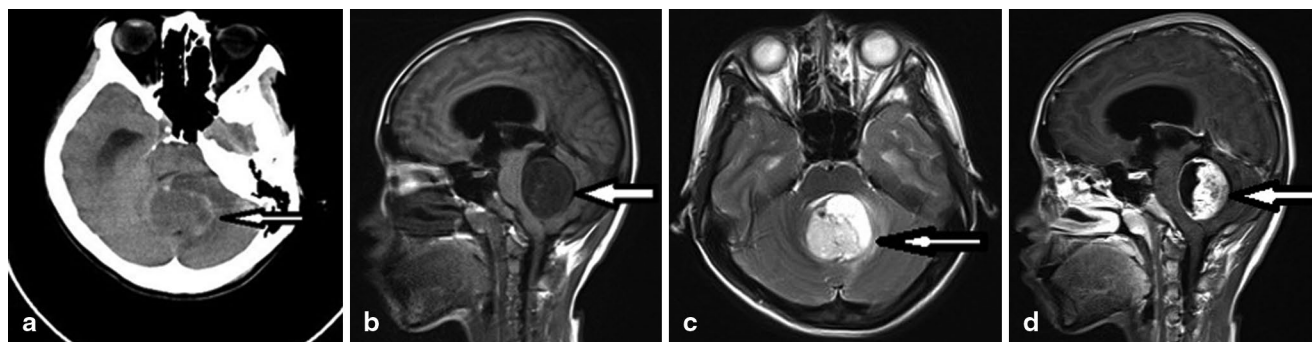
Mixed cystic and solid pilocytic astrocytoma in the fourth ventricle. a Computed tomography scans suggest an oval low-density lesion in the fourth ventricle that was surrounded by calcification (*arrow*). b Sagittal T1-weighted magnetic resonance (MR) images show the lesion at low signal intensity with clear margins (*arrow*) and an enlarged supratentorial brain ventricle. c Axial T2-weighted MR
